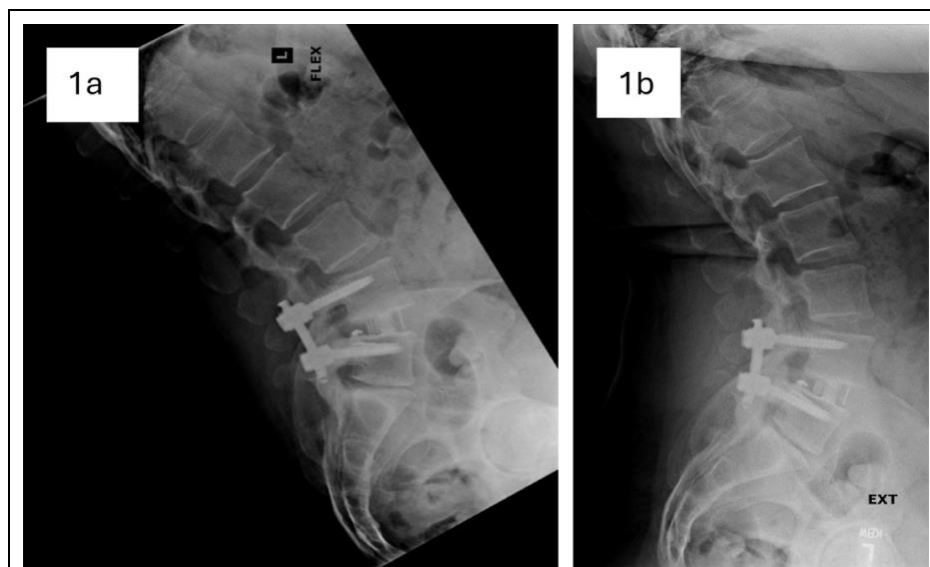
Flexion (a) and extension (b) X-rays at 12 months demonstrating stable posterior instrumentation at L4-L5 with satisfactory alignment and bony bridging between the vertebral bodies.
